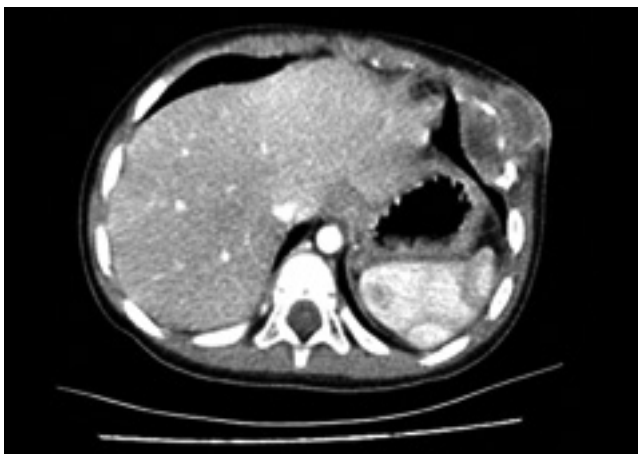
On thorax CT examination: A mass lesion on the 6th rib, 26x33mm in size, hypodense in the center, cystic-necrotic structure, hyperdense solid in the periphery, peripherally contrasting, expanding-destroying the rib and extending into the soft tissue.
